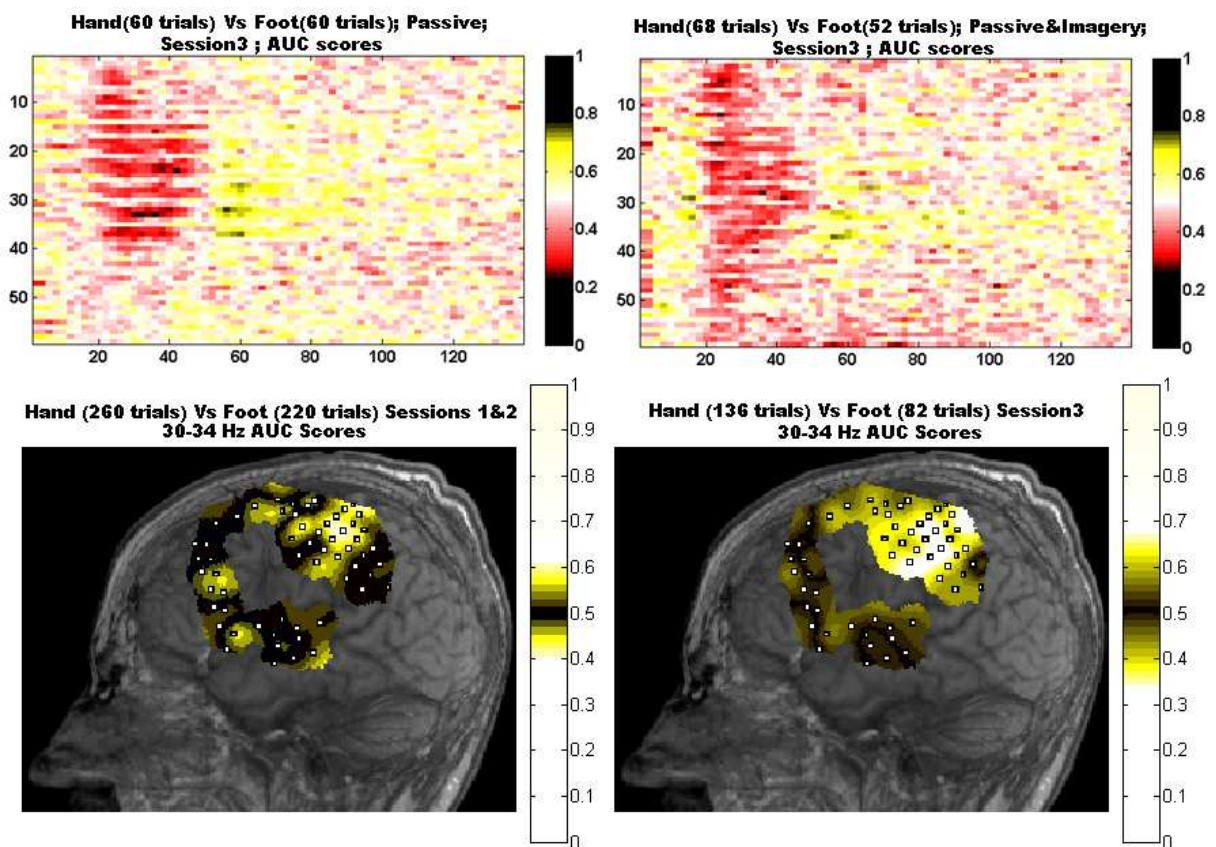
ECoG activity during passive movement: On the top area under the curve (AUC) scores comparing foot versus hand movements of Session 3 (CLIS); On the left side passive movements alone and on the right passive movements and motor imagery simultaneously AUC scores. In black the values that are statistically significant comparing hand versus foot movements. At the bottom the AUC scores in the frequency bin from 30 to 34 Hz plotted on the ALS patient X-Rays (left, sessions 1&2 LIS and right, session3 CLIS) comparing hand versus foot passive movements. In white the statistically significant AUC values. The hole in the center of the electrode grid is due to high impedances or lost channels.
